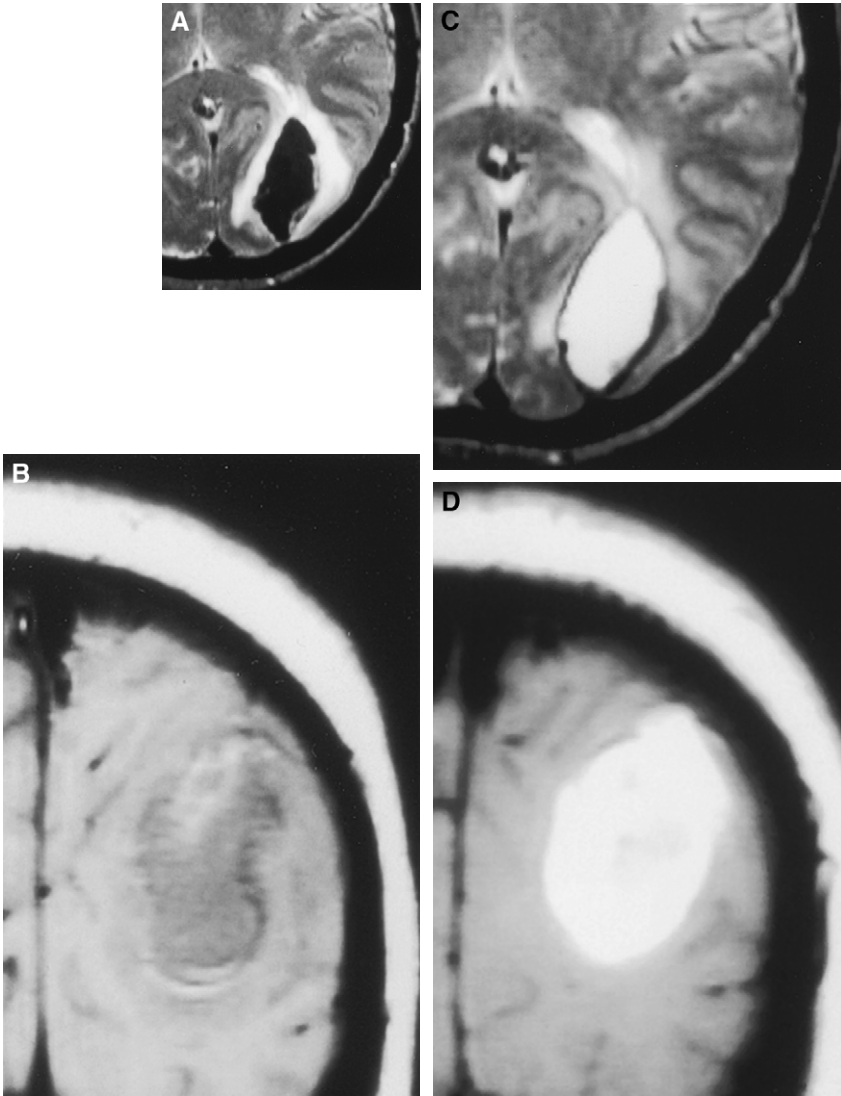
MRI studies obtained 36 hours and 10 days after the clinical event. (A,B) Acute left occipital hematoma. Note decreased T2 (A) and T1 (B) signals in the center of the hematoma as a result of deoxyhemoglobin. A small amount of intracellular methemoglobin has already formed at the periphery. Surrounding increased signal on a T2-weighted image (T2WI) reflects vasogenic edema and extracted serum. In the late subacute stage, the hematoma demonstrates markedly increased signal on both a T2WI (C) and a T1-weighted image (D) because of extracellular methemoglobin.
